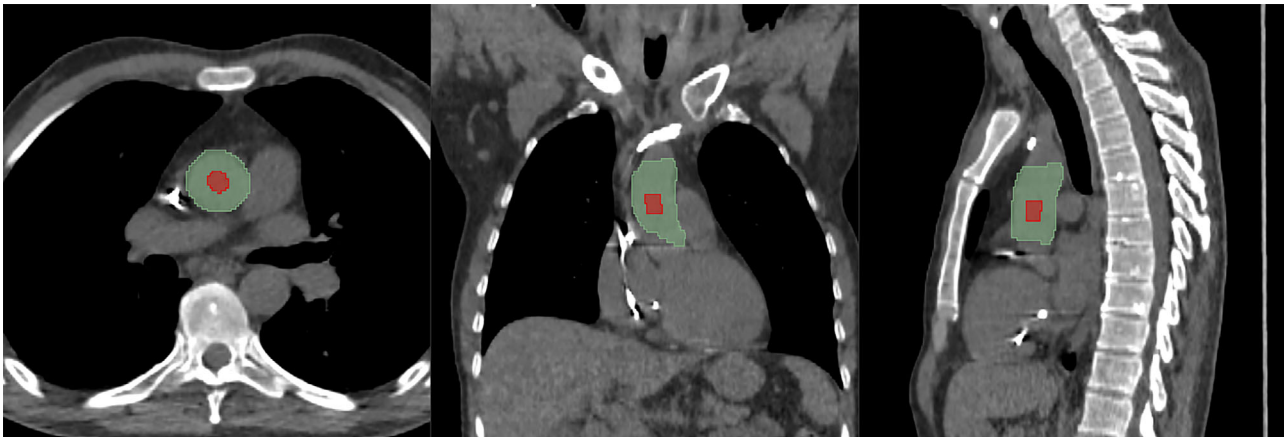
Axial, coronal, and sagittal planes through the CT image of a patient fused with the ascending aorta segmentation (green) and with background segmentation (red). Note that CT artifacts are due to a pacemaker lead in the vena cava.
